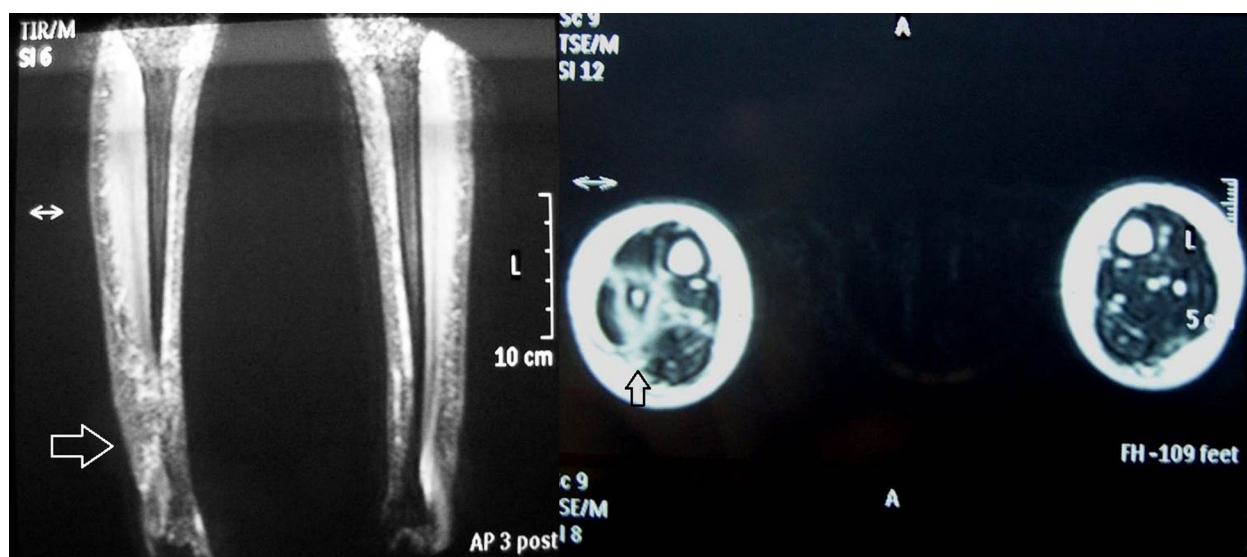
Localized paracoccidioidomycosis, case 5. Osteolytic lesion in the leg diaphysis (arrows) observed using X-ray (left image) and computed axial tomography (CAT, right image). This Figure is reproduced in color in the online version of *Medical Mycology*.
